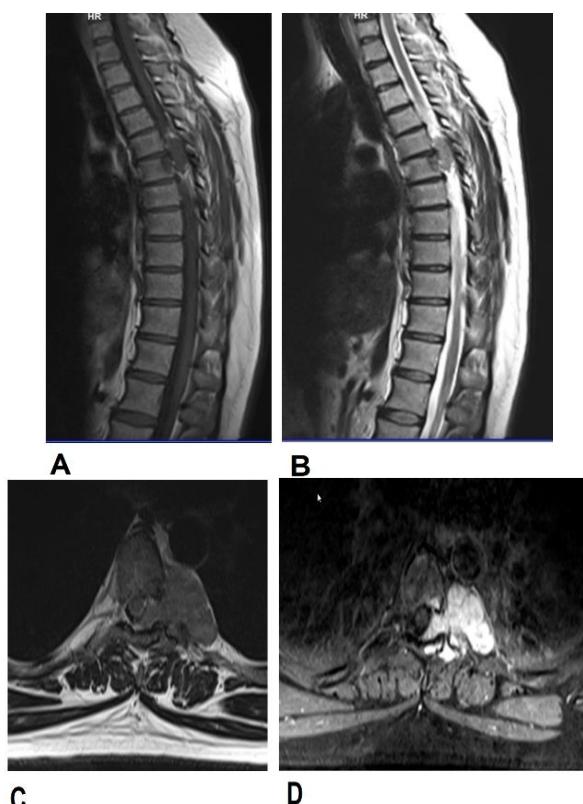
A-D) Magnetic resonance imaging (MRI) of the thoracic spine showing an infiltrative extradural soft tissue mass in the left paravertebral area without vascular involvement. The lesion has low signal intensity on T1-weighted images and high signal intensity on T2-weighted images
